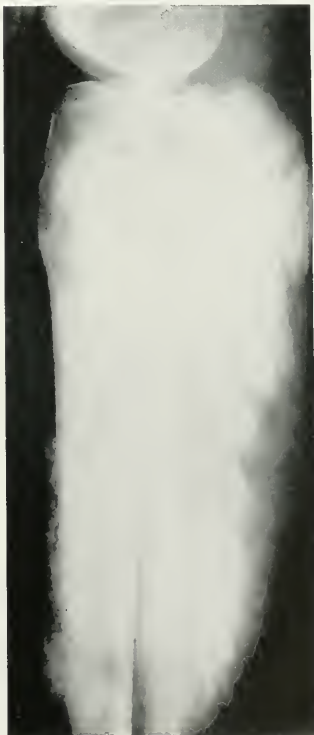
Pathol. No. 27702. Case 7. X-ray, 1 12/1923. Benign (?) excessive bone formation three years after resection of the upper end of the fibula for tumor shown in Figure 12.
